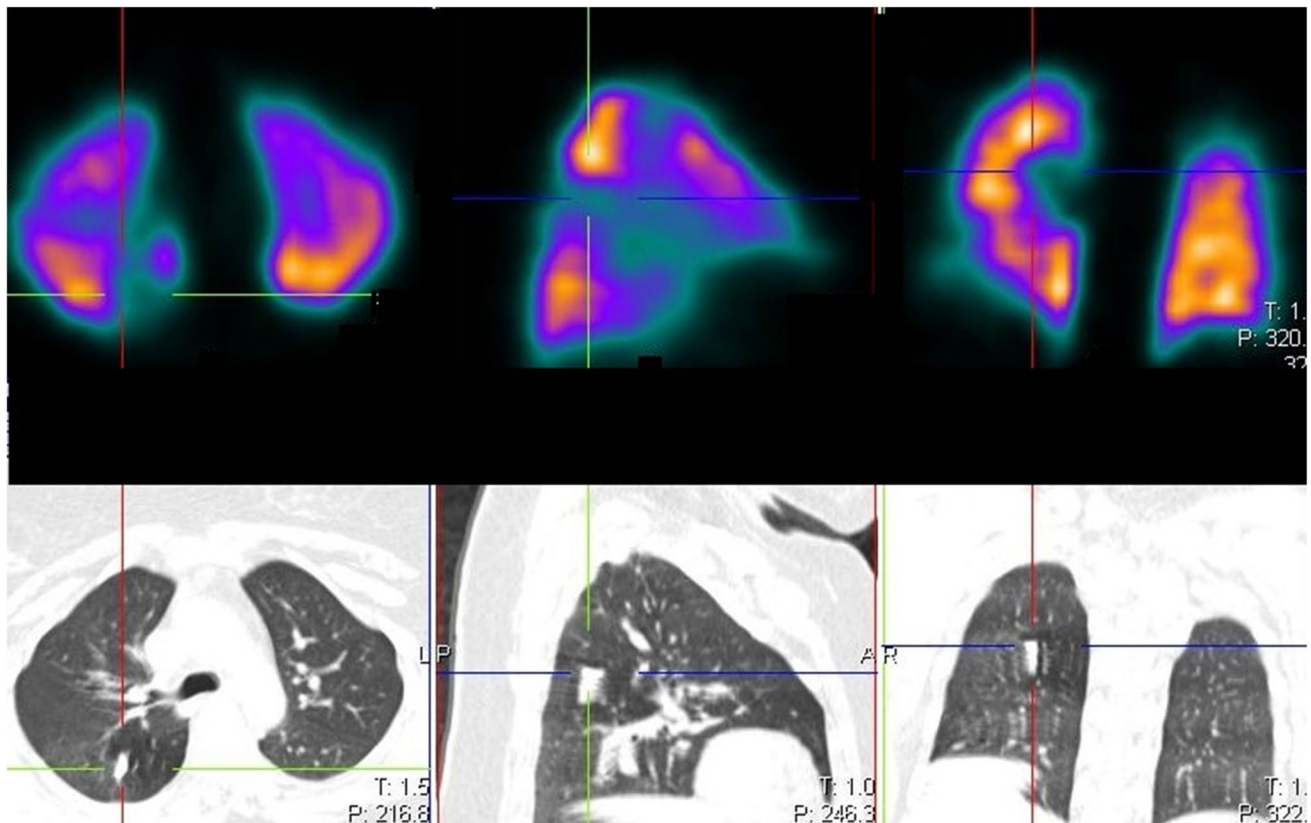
Perfusion SPECT (above) and CT (below) of the same patient in Fig. 2 a, performed 1 year after the baseline study, showing persistence of the defect, despite being on anticoagulation therapy for 6 months. Note that the calcification is still present
